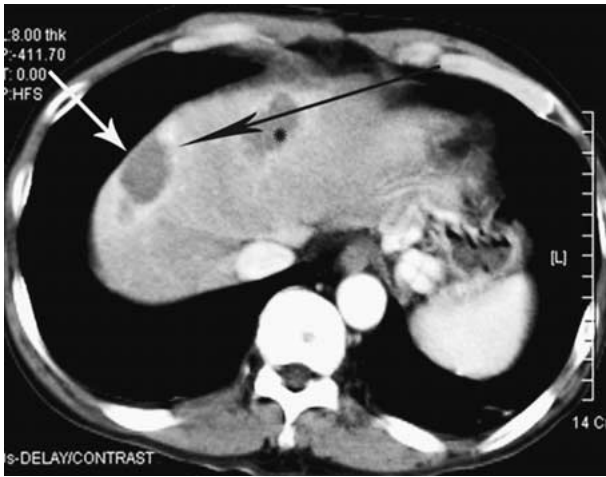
A 63-year-old male with hepatocellular carcinoma in liver segment 8 that shows a poor approach path: ablation of mass from the left subcostal approach. The hepatocellular carcinoma at segment 8 (*white arrow*) is not seen on the right intercostal or subcostal ultrasonogram in the supine position due to overlying lung parenchyma. In the right anterior oblique position, the mass is barely seen on the intercostal scan, but the electrode entry site is overlapped by the costochondral junction. Thus, the electrode is inserted from the left subcostal area into the segment 8 lesion (*black arrow*). Another ablated area for another lesion (*asterisk*).
